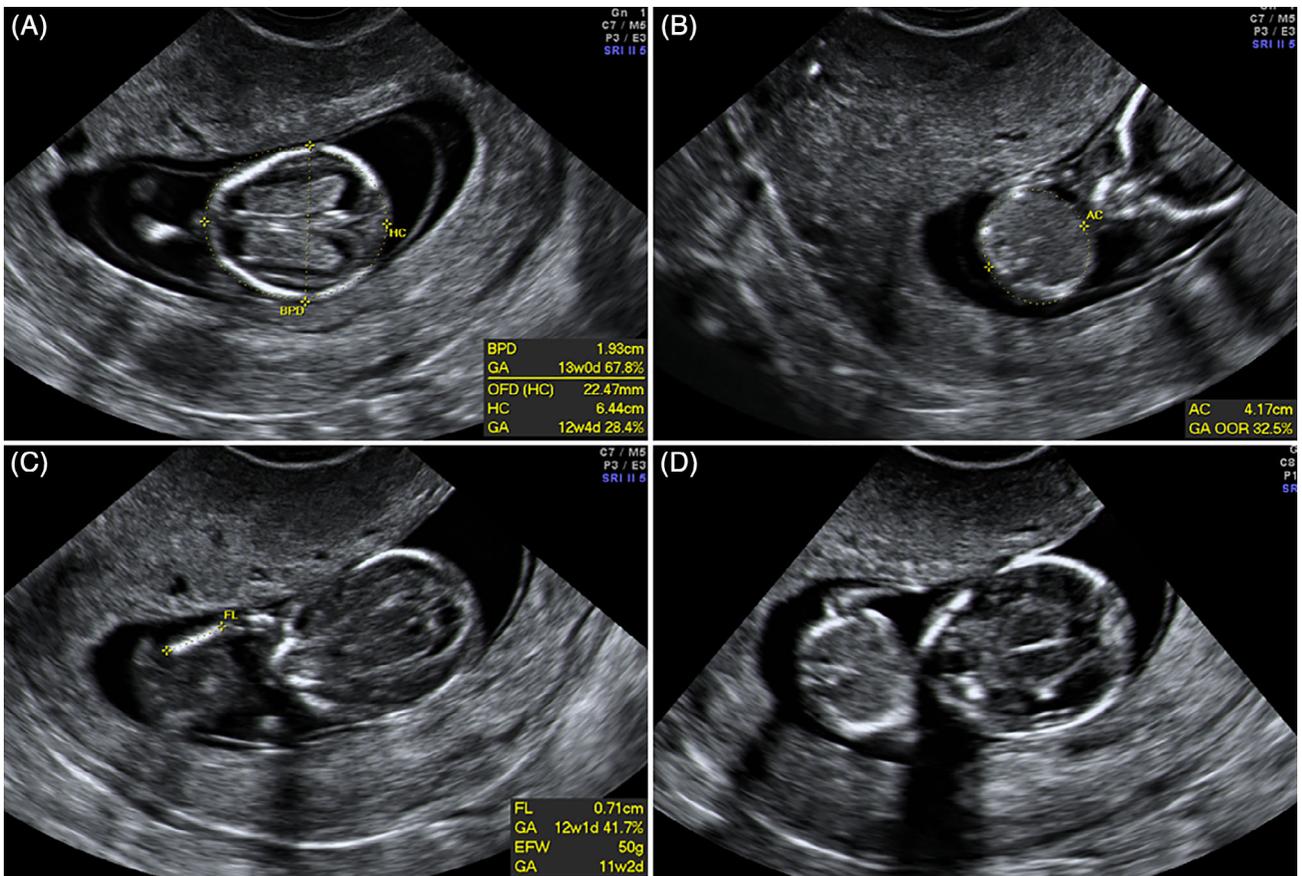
Triploidy of maternal origin at 12.2 weeks of gestation, referred because of an abnormal combined test with low pregnancy-associated plasma protein A (0.050 MoM). On ultrasound notable asymmetrical growth restriction; severe head-to-abdominal circumference discrepancy (A,B,C,D)
